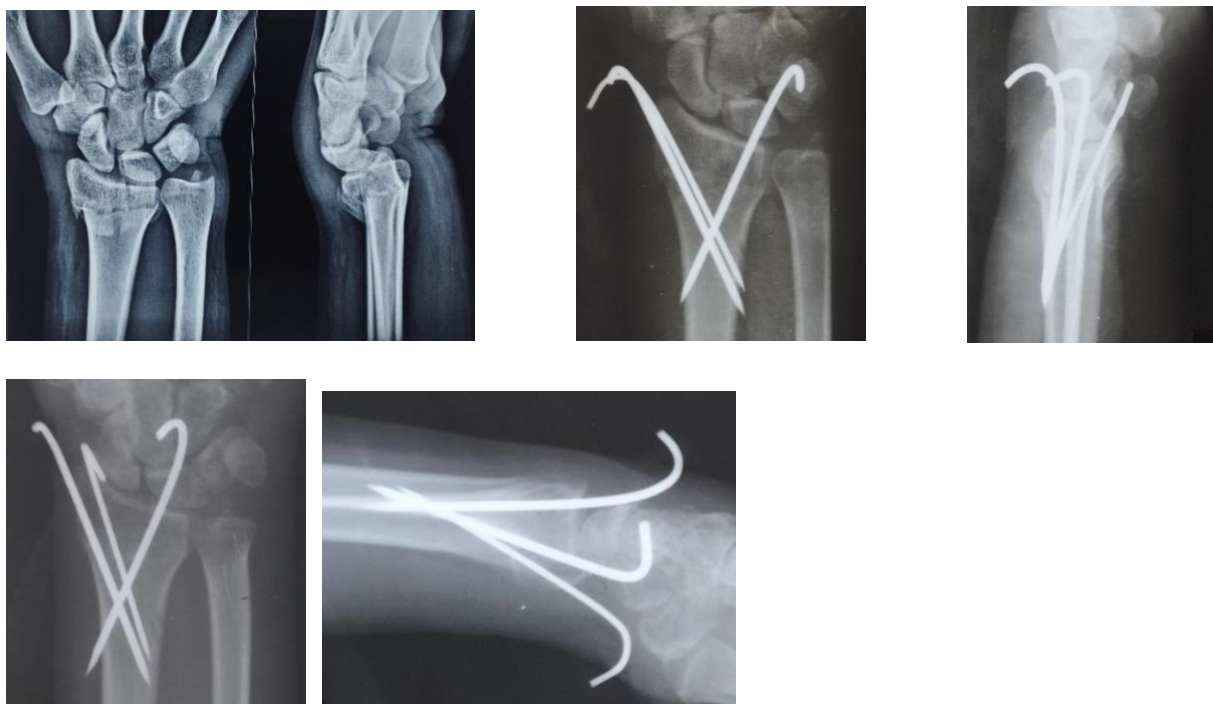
Pre-operative, postoperative and 1 month follow-up X-rays showing successful early bony union, when supported by ligamentotaxis, in a patient having volar ulnar fracture fragment fixed percutaneously by K-wire.
